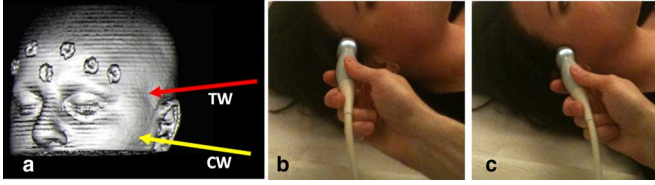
Rendering of proton density MRI (a), with arrows pointing the temporal and condylar windows. Probe position for the US examination through temporal (b) and condylar (c) windows.
